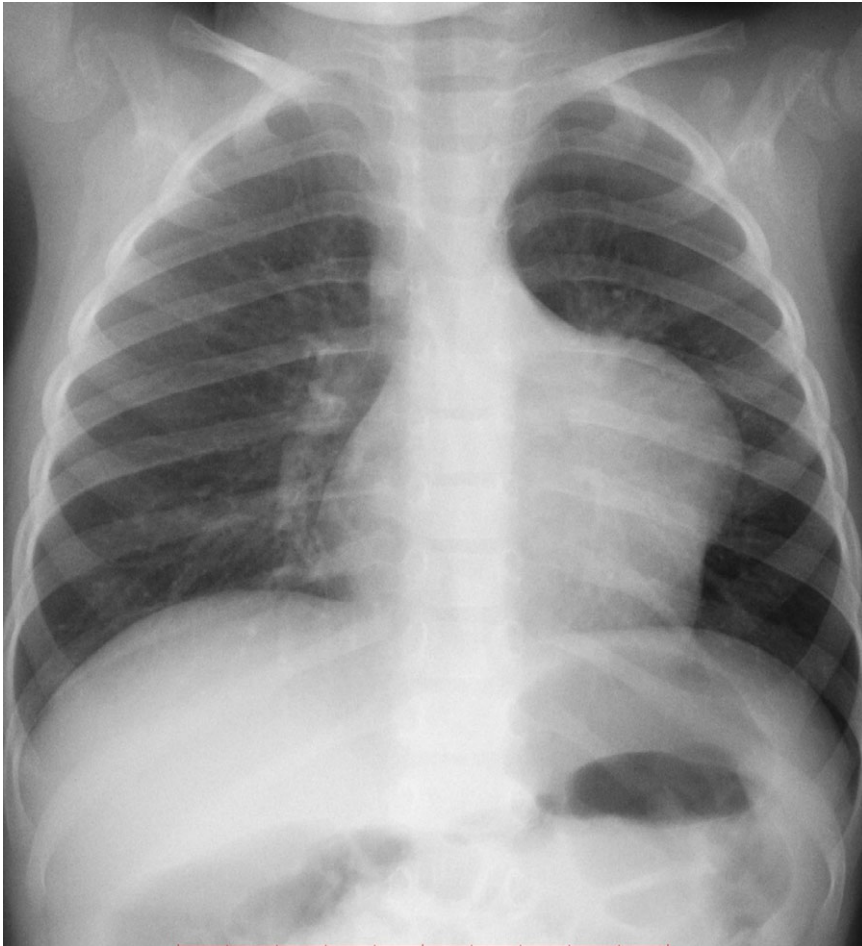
Preoperative chest radiography. Notice the remarkable bulging of the upper-left edge of the heart outline.
